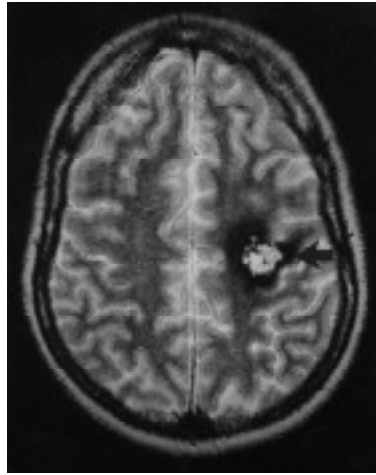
Same patient as Fig 5a. Axial gradient echo T2-weighted MR image shows a prominent low signal intensity rim of haemosiderin (arrows), typical of cavernous venous malformation.
